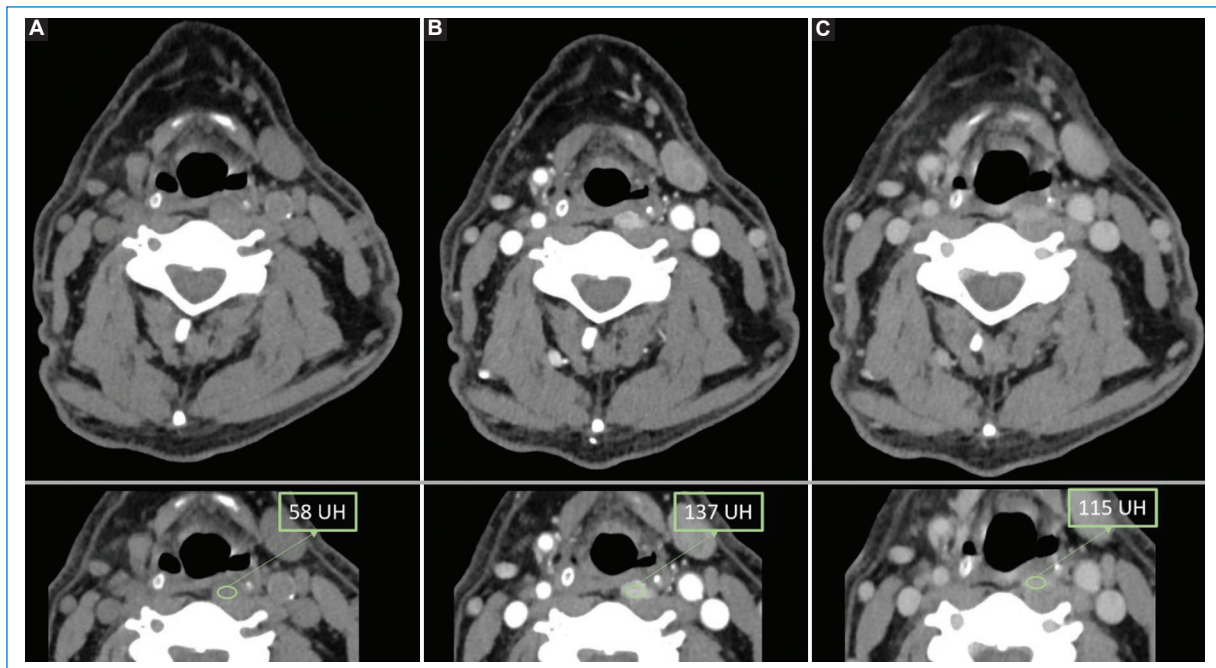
Dynamic 4D computed tomography scan of the parathyroid glands in non-contrast (A), arterial (B), and venous (C) phases, showing the characteristic enhancement pattern of a parathyroid adenoma, with intense enhancement on the arterial phase and washout on the venous phase.
